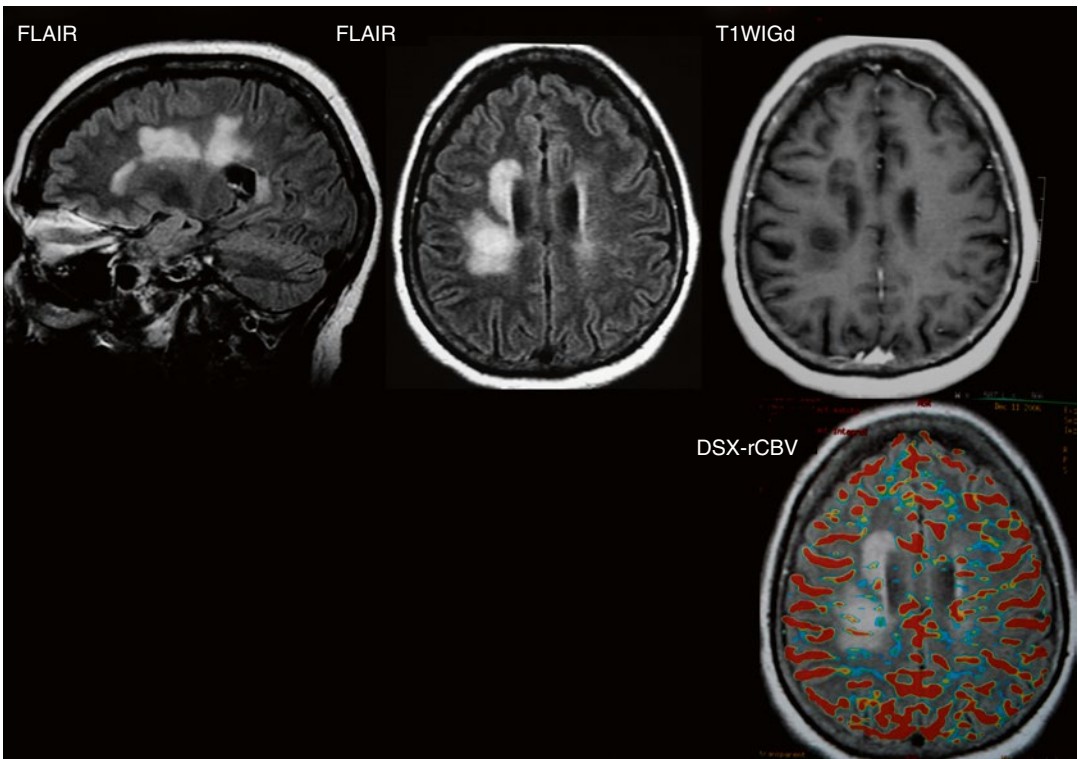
A demyelinating lesion that does not enhance after endovenous contrast administration is seen at the right centrum semiovale in a patient with multiple sclerosis. DSC-MRI demonstrates the presence of vessels within the lesion
